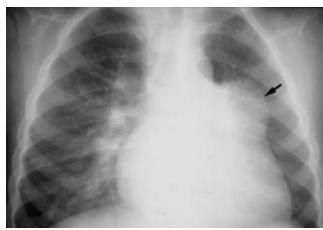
Aneurysmal dilatation of the reconstructed right ventricular outflow tract (RVO). A. Cine MR image in right anterior oblique view shows an aneurysmal dilatation of the right ventricular outflow tract (RVO). B, C. Chest radiogram and radioisotope perfusion lung scan from another patient. The aneurysmal dilatation of the reconstructed right ventricular outflow tract and main pulmonary artery (arrow) is seen in the left upper heart border. There is very little perfusion to the left lung owing to severe compression of the left pulmonary artery by the aneurysmal sac. RA, right atrium; RV, right ventricle.
